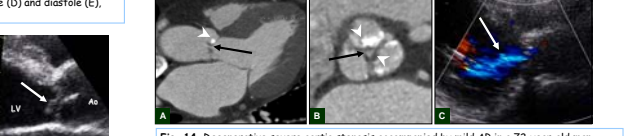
Degenerative aortic valve disease accompanied by mild AR in a 72-year-old man. Multiplanar reformatted CT images (A, B) - Thickened, calcified cusps of aortic valve (arrowheads) and incomplete coaptation (arrows) on mid-diastole (A, B). Echocardiographic image (C) - A central jet regurgitating into the left ventricle during diastole (mild AR, arrow).
